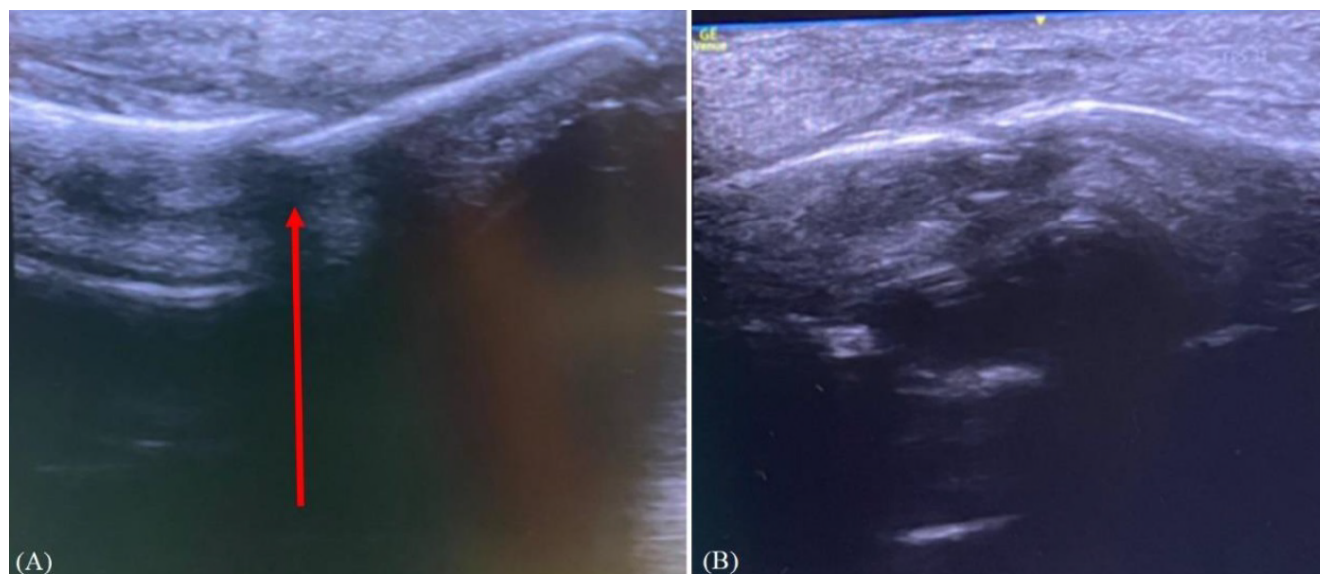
(A) Ultrasound scan showing nasal bone fracture (red line) (transverse plane). (B) Ultrasound scan showing nasal bone without a fracture (transverse plane).
